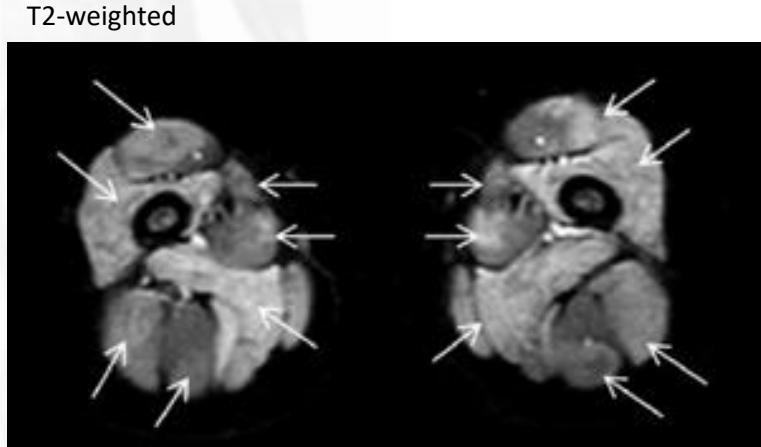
Skeletal muscle tissue characterization by NMR imaging. Comparison of qualitative and quantitative approaches. CSA: cross-sectional area; UTE: ultra-short echo time; DEMRI: delayed enhancement MRI; Fat Sat: fat saturation.
